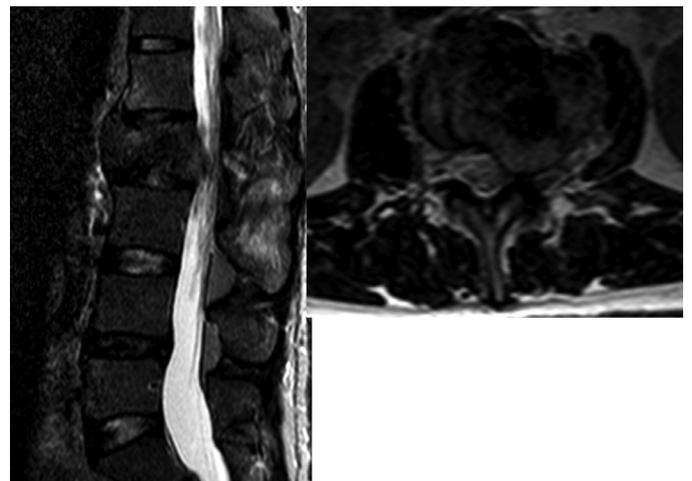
Sagittal and axial sections of the T2-weighted lumbar spinal magnetic resonance imaging demonstrating heterogeneous hypo- and hyperintense tumor in the L2 vertebral body compressing the nerve roots
